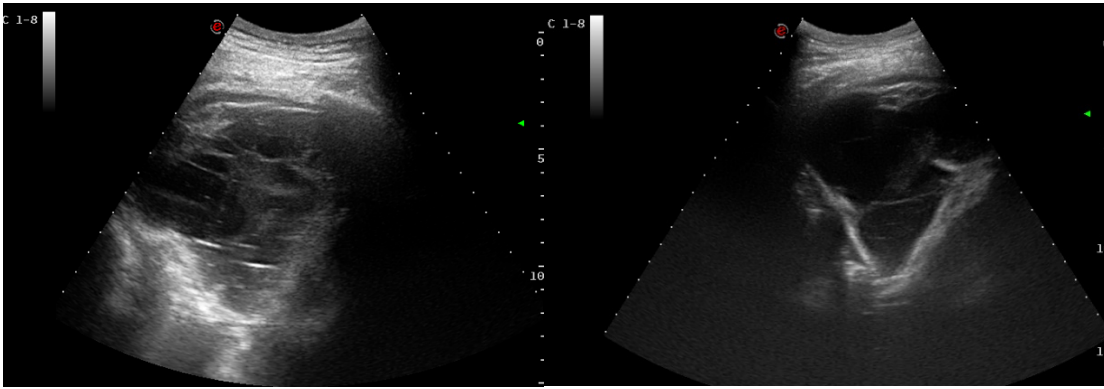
Ultrasonographic image of saccated right lung pleural effusion with presence of fibrin shoots.
